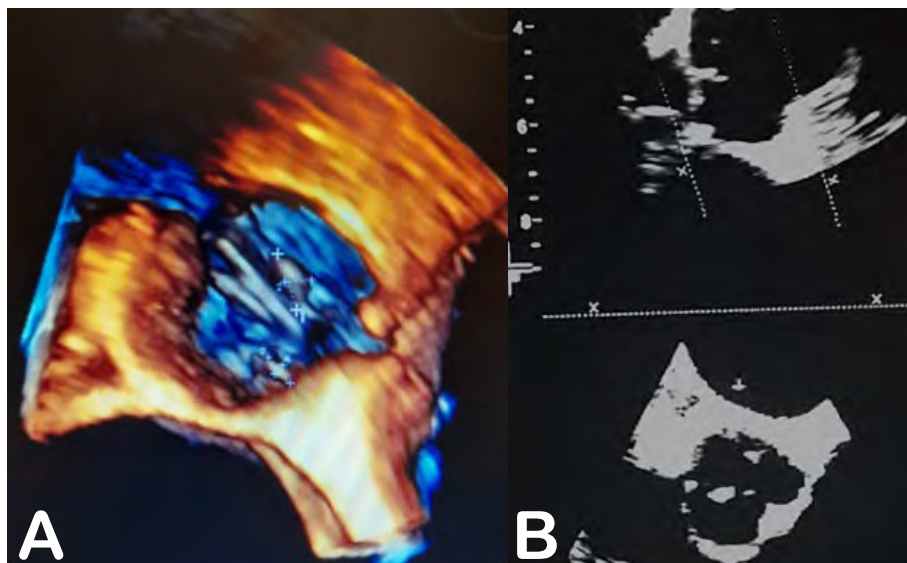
Aortic fibroelastomas located in the right coronary cusp (13 mm by 3 mm) and left coronary cusp (10mm by 3 mm) observed in transesophageal echocardiogram in 3D (A) and in 2D (B).
